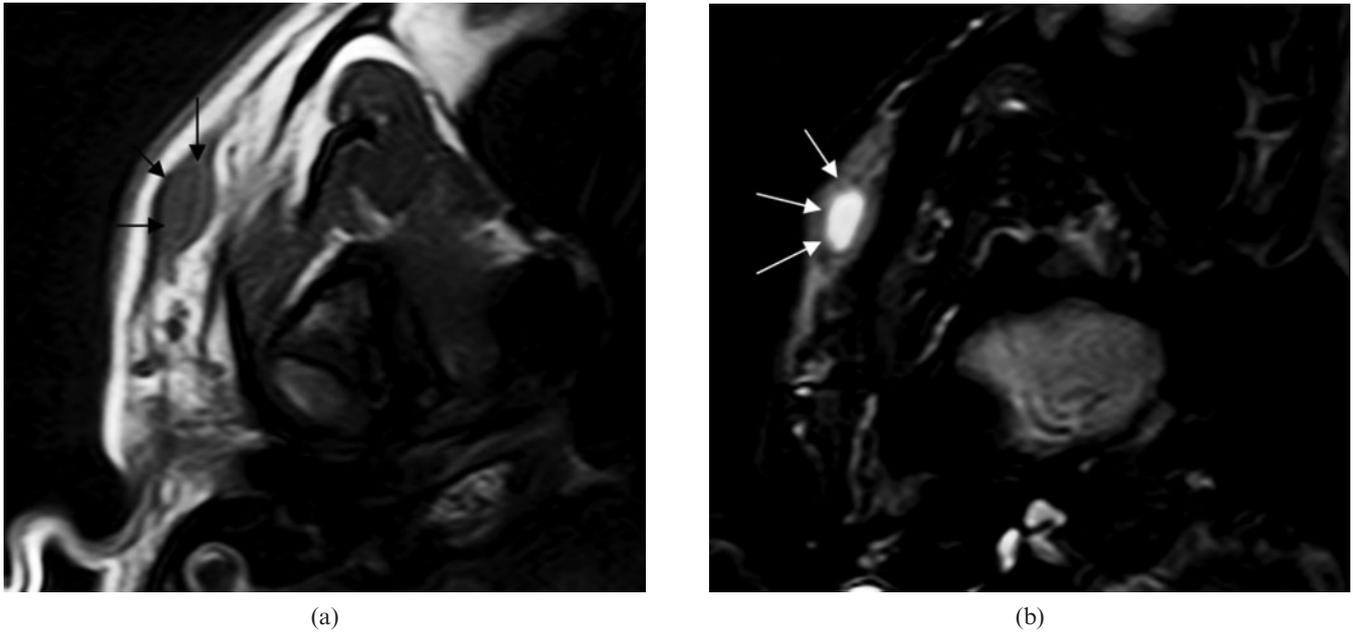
(a) Axial T_1 weighted and (b) short tau inversion recovery (STIR) MRI show a small cystic, encapsulated lesion in the subcutaneous soft tissues overlying the right zygomatic arch (arrows).
